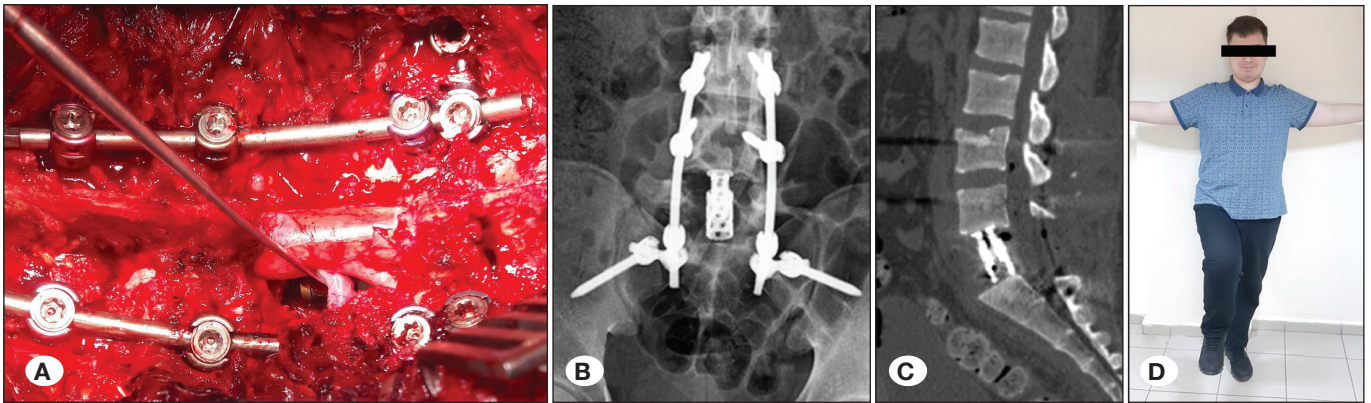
Case #6 (Cont.). A) An intraoperative photo showing the extent of decompression, cage replacement, and L₃-sacropelvic instrumentation. B) Postoperative lumbosacral AP X-ray, and C) sagittal CT sections. D) The patient's final neurological condition at the last follow-up.
